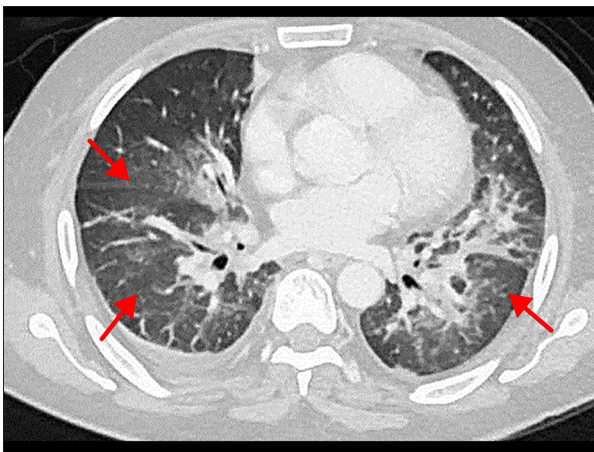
Computed tomography (CT) scan Thorax (Red arrows: Patchy consolidation and air bronchograms consistent with ARDS).
